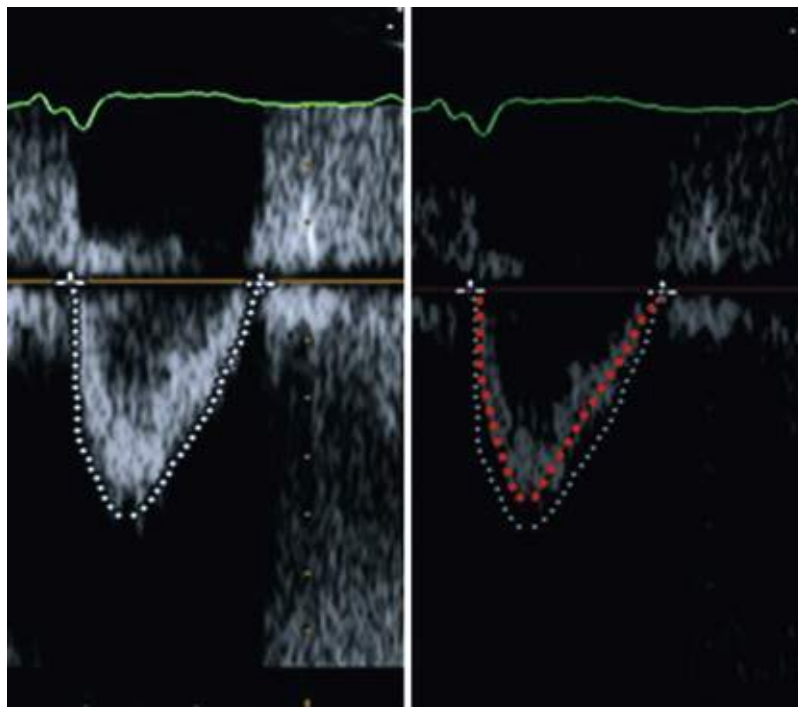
Doppler spectra demonstrating the error that may be introduced if the maximal (*white dotted line*) rather than the modal (*red dotted line*) velocity is measured. The modal velocity (the most commonly occurring velocity) corresponds to the brightest portion of the Doppler spectrum.
